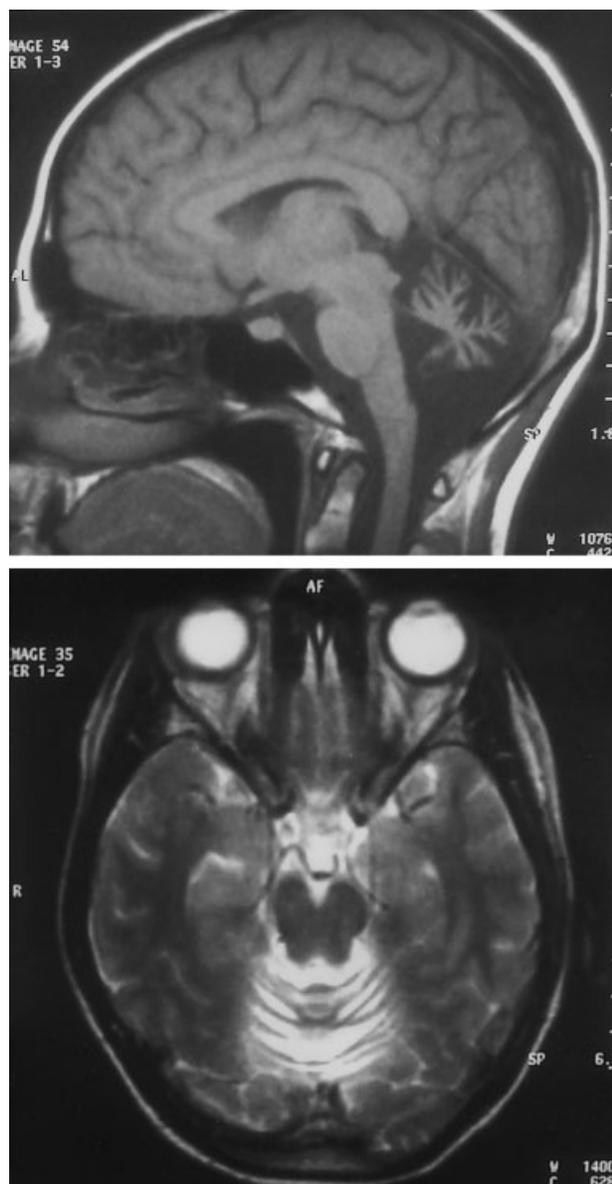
Magnetic resonance imaging scan of the brain. A: A sagittal T1-weighted image demonstrates marked atrophy of the vermis and cerebellar hemispheres without any pontine involvement. B: An axial T2-weighted image confirms atrophy of the vermis and cerebellar hemispheres.
